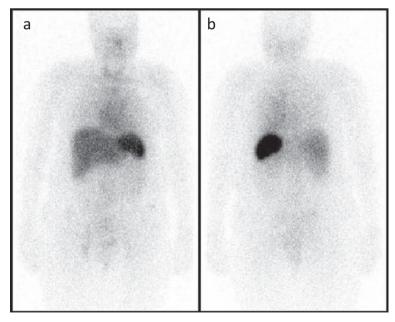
Whole-body, 123-iodine-labelled serum amyloid P component (SAP) scintigraphy showing uptake in spleen on anterior (a) and posterior (b) views.
